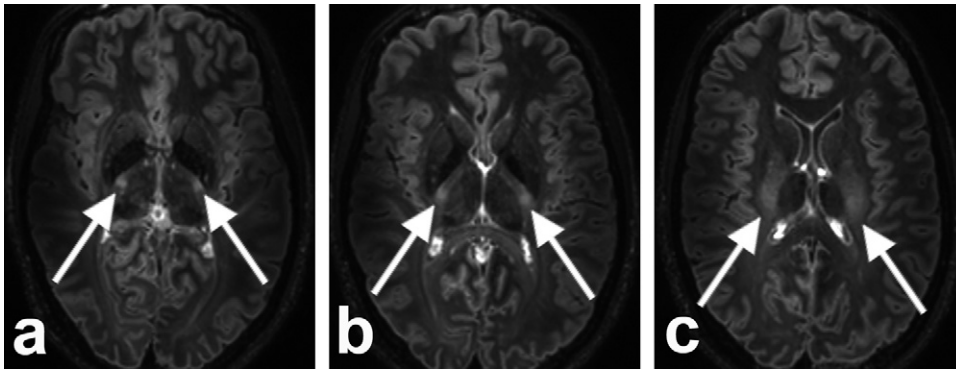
a–c, Axial reformats of a 3D FLAIR dataset of a 26-year-old healthy female volunteer, showing, among others, the basal ganglia, choroid plexus (hyperintense signals in the ventricles) and the corticospinal tract (arrows) as it ascends to form the internal capsule (b) and then fans out throughout both hemispheres (c). Imaging parameters as previously published [3], 0.8 mm isotropic resolution.
